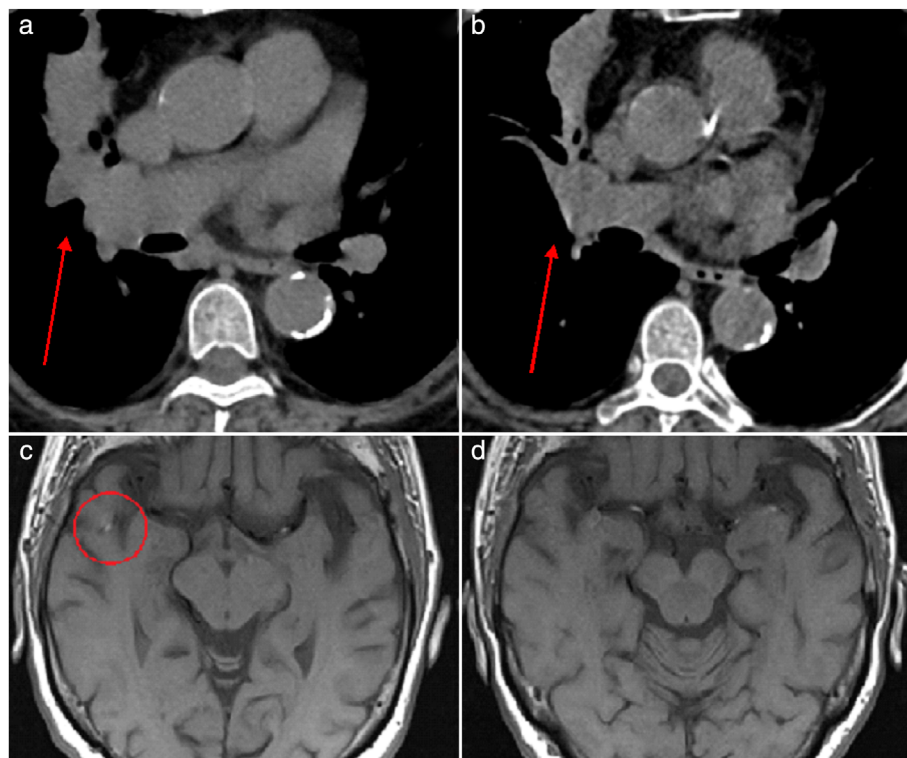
Mediastinal and brain radiological response upon treatment with afatinib. Comparison between CT scans of (a) June 2020 and (b) October 2020 and between (c) brain MRI of July 2020 and (d) February 2021
